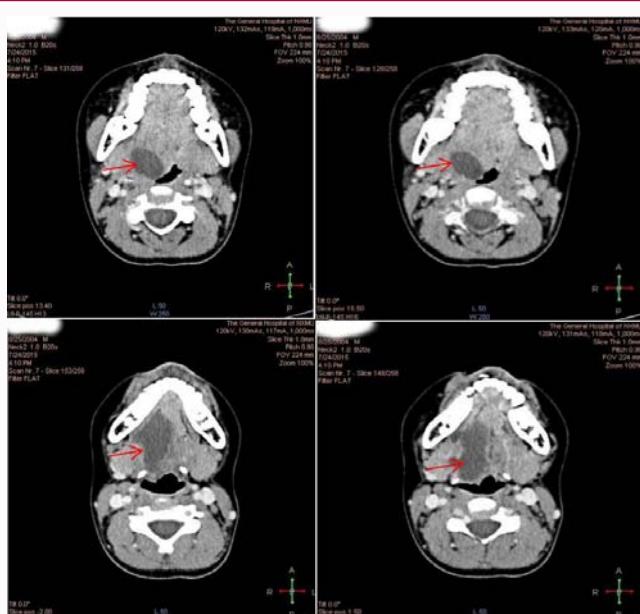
Initial contrast-enhanced Axial Computed Tomography of Siemens 64 rows spiral CT (KV 120, mA 118, slice thickness 1 mm). Enhanced CT showed the lesion with low-density shadow at different levels as the fluid of sublingual gland cyst extending into the sublingual, parapharyngeal spaces.
